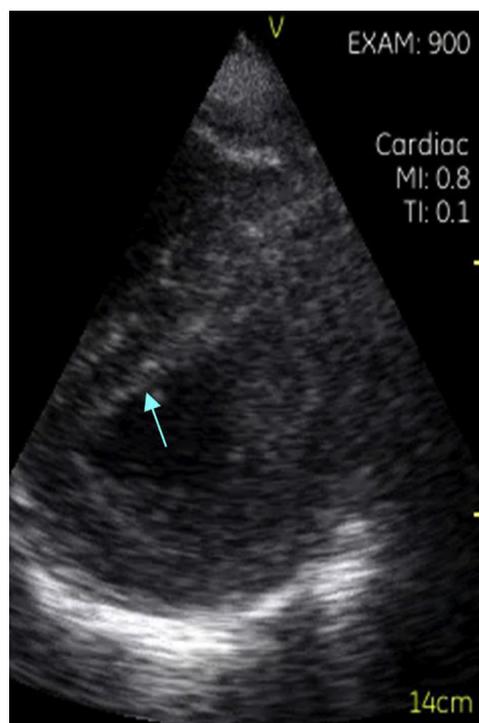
Focused cardiac ultrasound parasternal short axis view demonstrates D-shaped septum consistent with right ventricular pressure overload (arrow).
